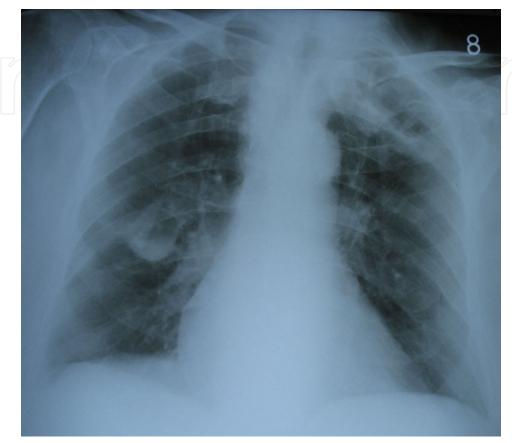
Follow-up chest radiograph (three weeks later) showing regression of mentioned pulmonary opacities.
